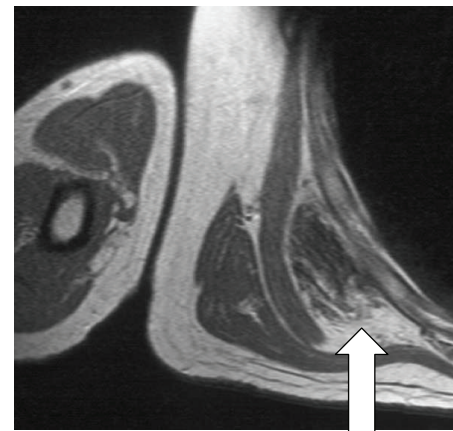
Axial T1-weighted MR image showing an elastofibroma as a soft tissue mass deep to the muscles and adjacent to the chest wall.
